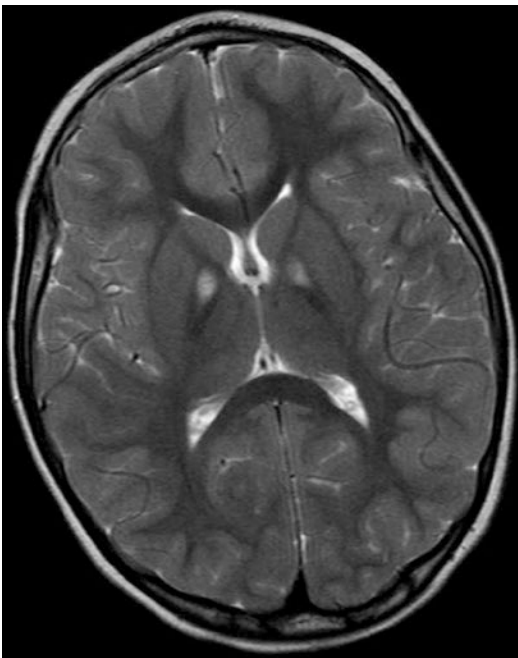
Eye-of-tiger sign in T2-MRI in PKAN: gliosis and increased iron content in pallidum
